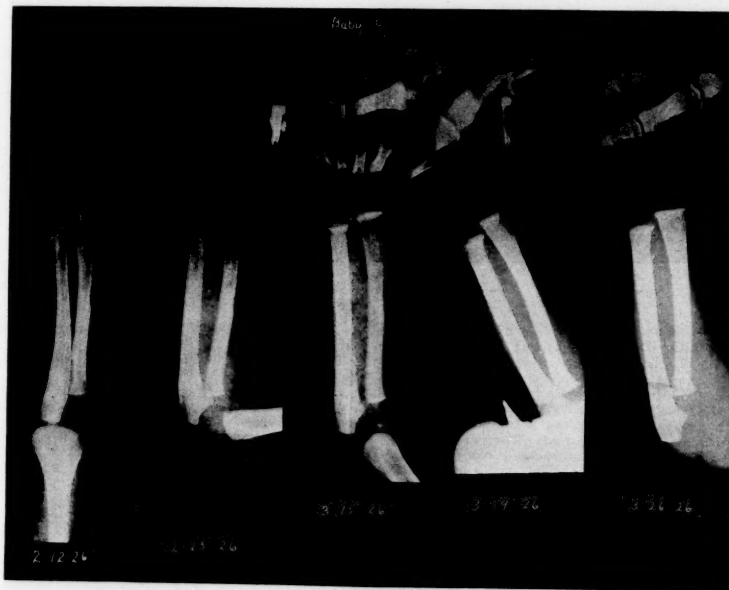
Case No. 2. J. C. Male aged 4 months treated with the sun's rays through quartz window panes. Roentgenograms show progressive increased calcification of the epiphyses and shafts with the appearance of the carpal centers of ossification.
